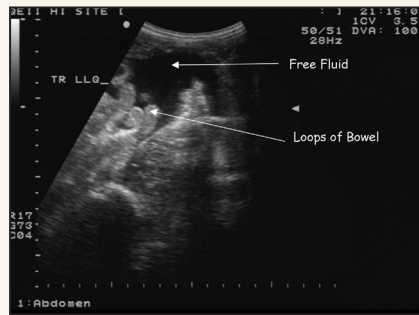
Ultrasound showing significant free intraperitoneal fluid.
